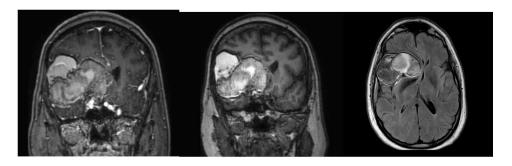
MRI of the brain. (A) Coronal T1-weighted imaging without contrast demonstrating a massive cyst 8.0 cm in oblique diameter with intrinsic T1-hyperintensity. (B) Same image after administration of gadolinium demonstrating relationship of the cyst to adjacent vasculature. Note early invasion of the lesion into the sella turcica. (C) Axial T2-FLAIR demonstrating intralesional heterogenous signal and 13mm of midline shift with effacement of the right frontal horn.
